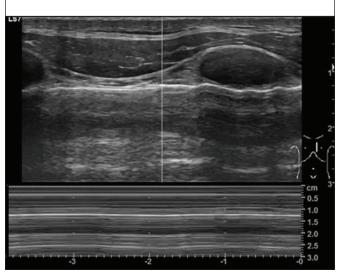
Ultrasound findings consistent with pneumothorax.
